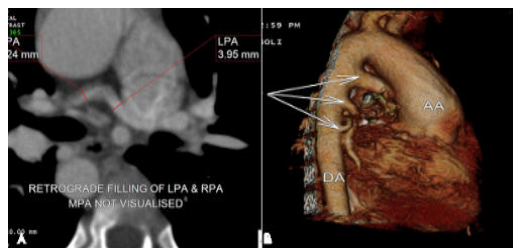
(A and B): Axial section and reformatted 3D image from cardiac CT describing pulmonary atresia with MAPCAs (white arrows) and dilated ascending aorta (AA).
